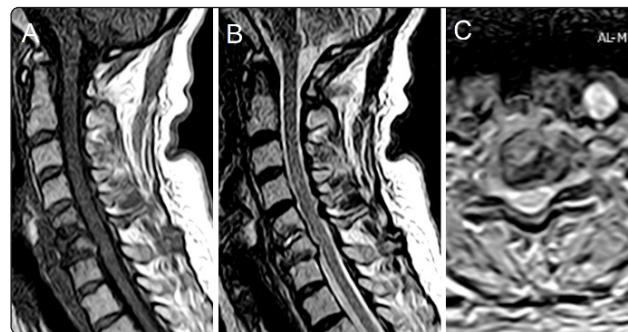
MRI of the cervical spine, (A) T1 image sagittal, (B) T2 image sagittal, (C) T2 image axial C5-C6 showing abnormal signal intensity at the levels of C5-C6 and C6-C7, with the hyperintense area at the disc level of C5-C6.
